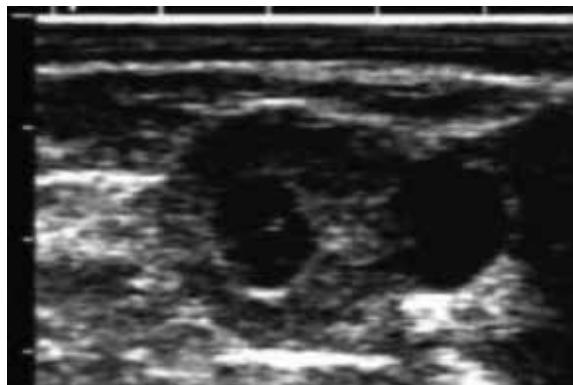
Ultrasound image of the buffalo ovary with a corpus luteum (on the left) and follicle (on the right).
